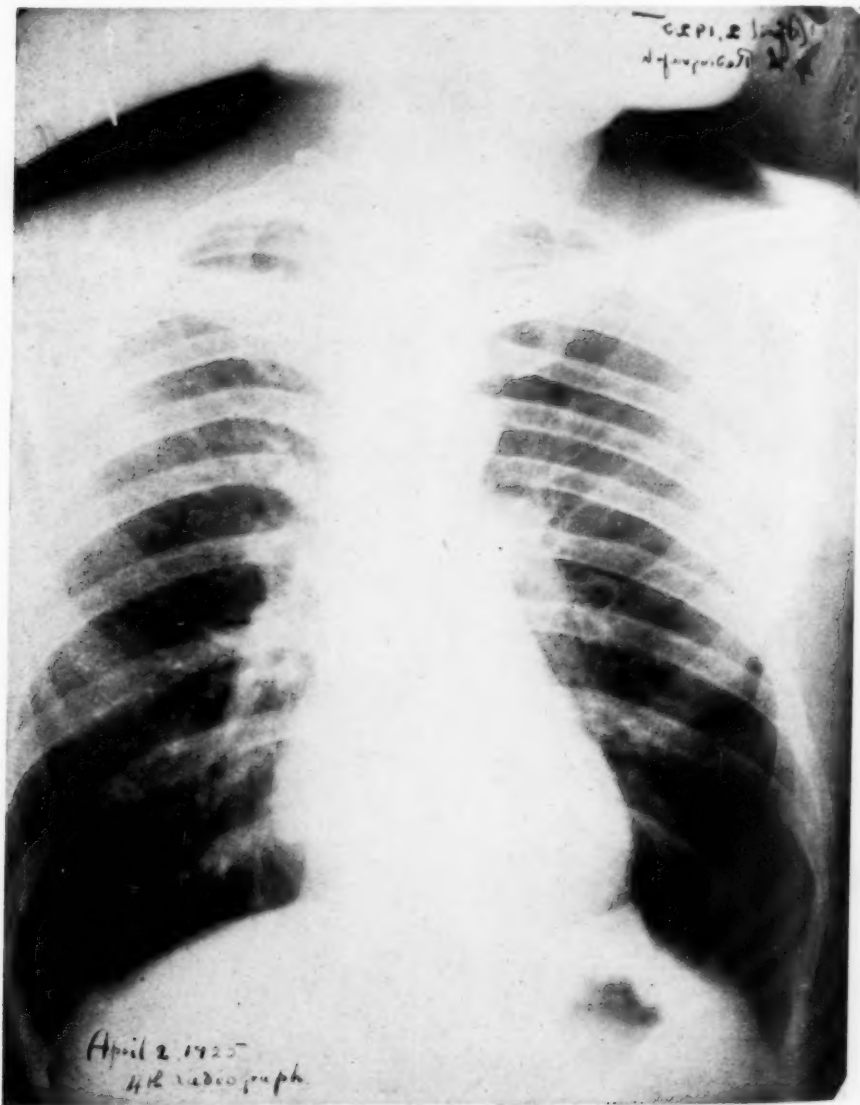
Radiograph of Case No. II two years after pneumothorax.
